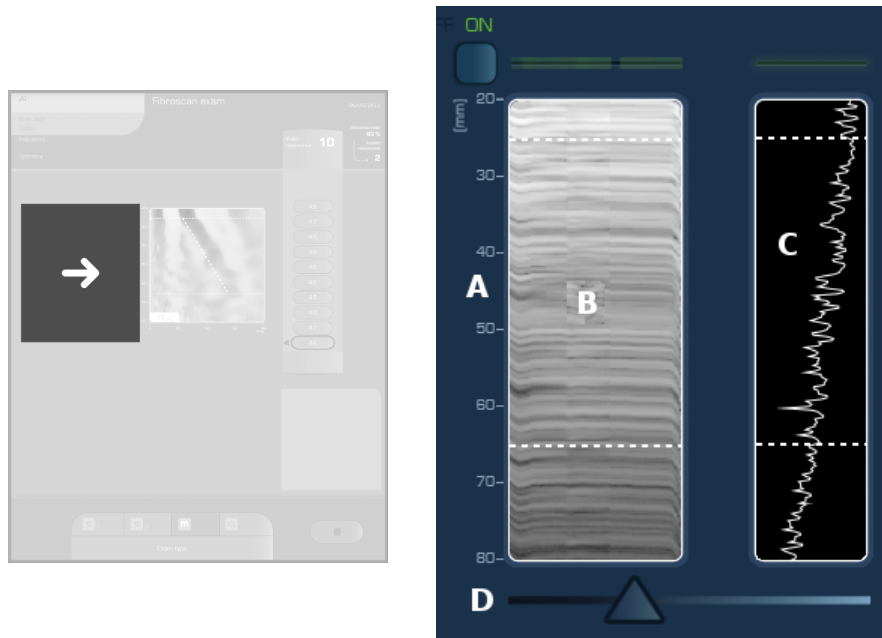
Image in TM (left) and Amplitude (right) modes: A: Depth explored (mm). B: Ultrasound signal represented in TM (Time Motion) mode. C: Ultrasound signal represented in A (Amplitude) mode. D: Display gain adjustment.
